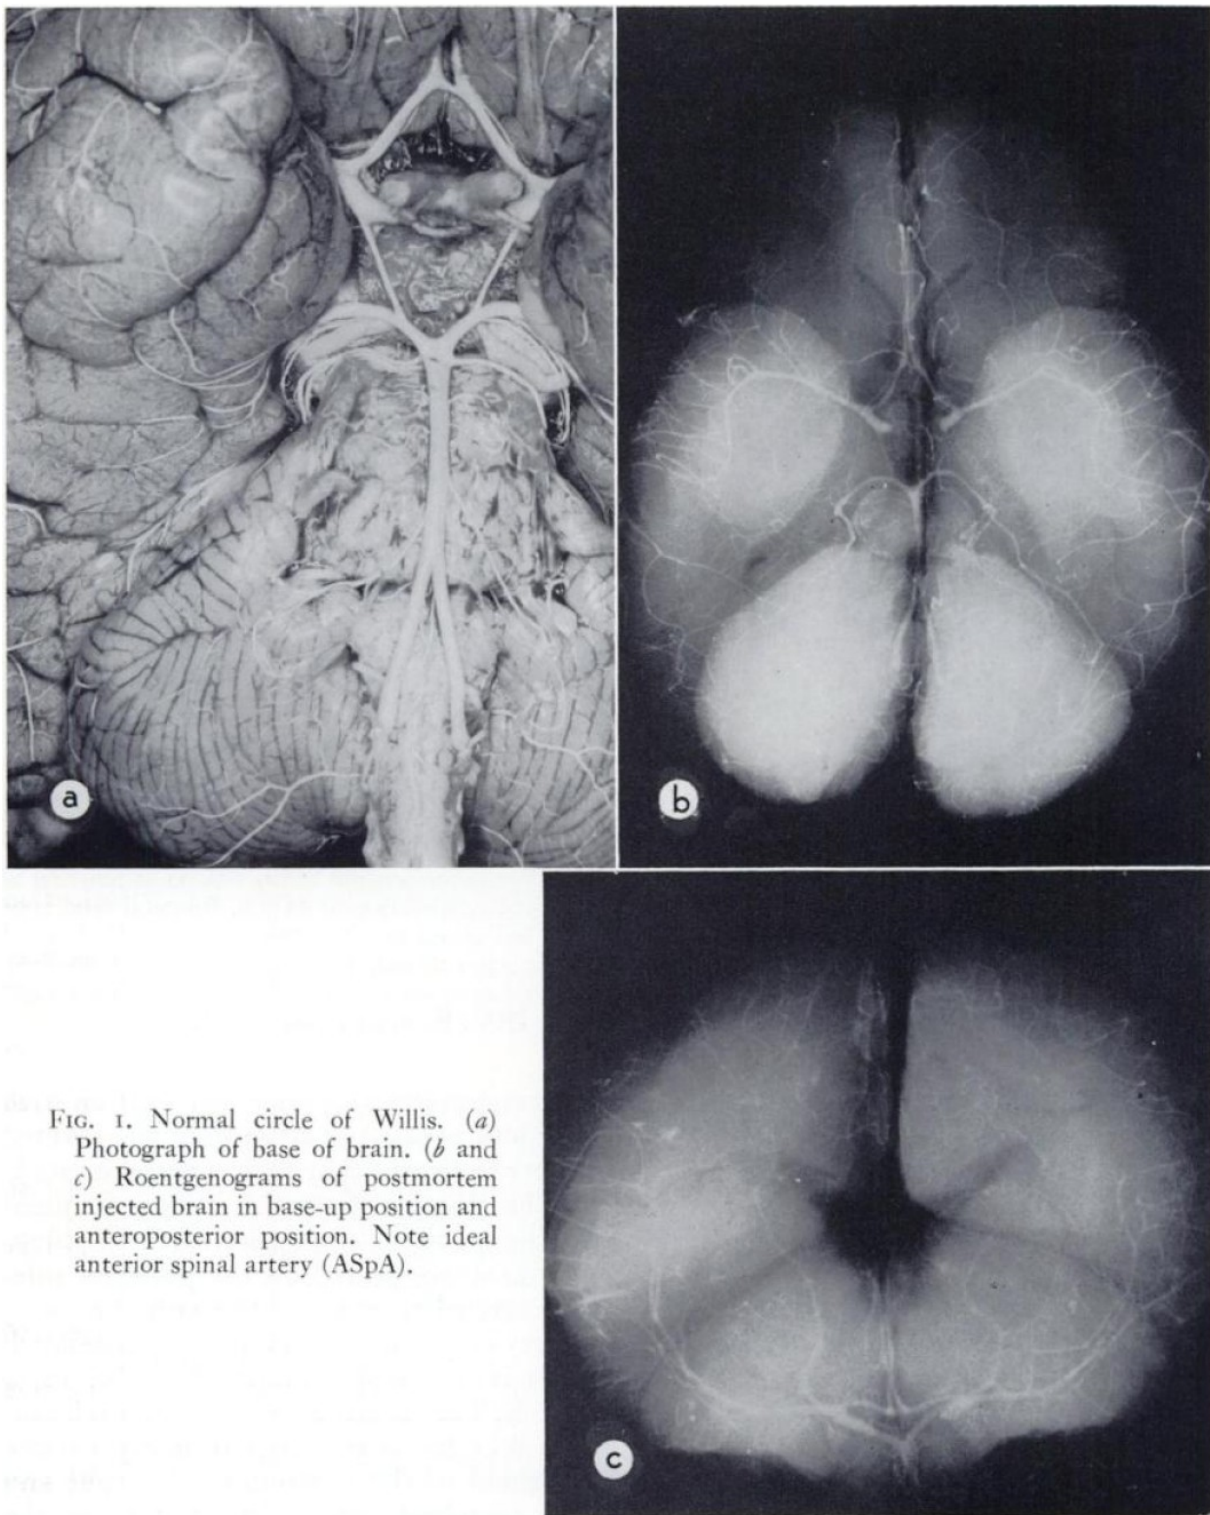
Normal circle of Willis. (*a*) Photograph of base of brain. (*b* and *c*) Roentgenograms of postmortem injected brain in base-up position and anteroposterior position. Note ideal anterior spinal artery (ASpA).
